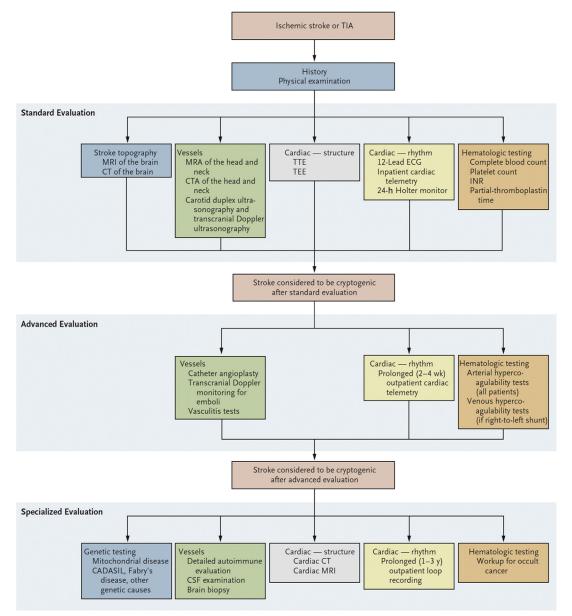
Algorithm for the identification and diagnostic evaluation of patients with cryptogenic ischemic stroke or transient ischemic attack (TIA). CADASIL, cerebral autosomal-dominant arteriopathy with subcortical infarcts and leukoencephalopathy; CSF, cerebrospinal fluid; CT, computed tomography; CTA, computed tomographic angiography; INR, international normalized ratio; MRA, magnetic resonance angiography; TEE, transesophageal echocardiography; TTE, transthoracic echocardiography. (*Reproduced from* Saver JL. Clinical practice. Cryptogenic stroke. N Engl J Med 2016;374(21):2068; with permission.)
